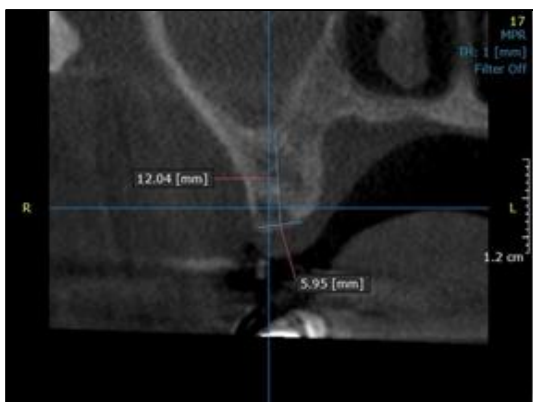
CBCT section of 17
